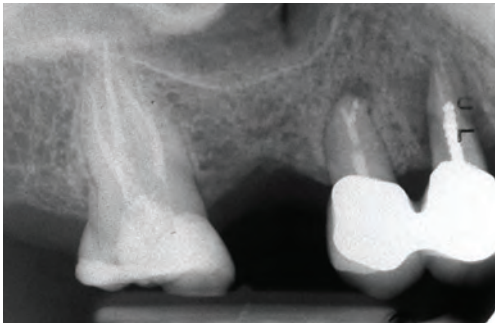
Pre-op periapical x-ray demonstrating presence of periapical pathology
